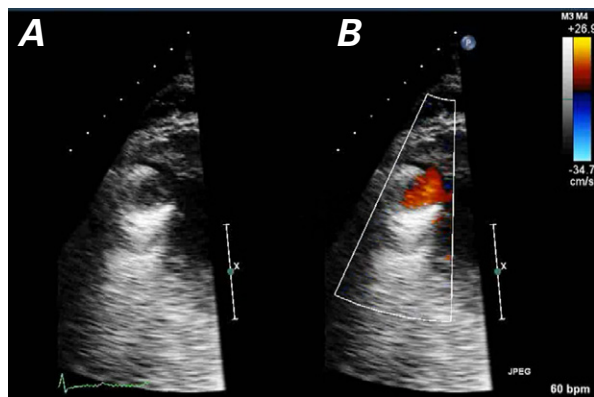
Transthoracic echocardiograms in A) 2-dimensional view and B) color-flow Doppler mode, obtained after left ventricular assist device deactivation, show a Doppler signal at the inflow cannula, suggesting retrograde aortic flow through the assist device.
